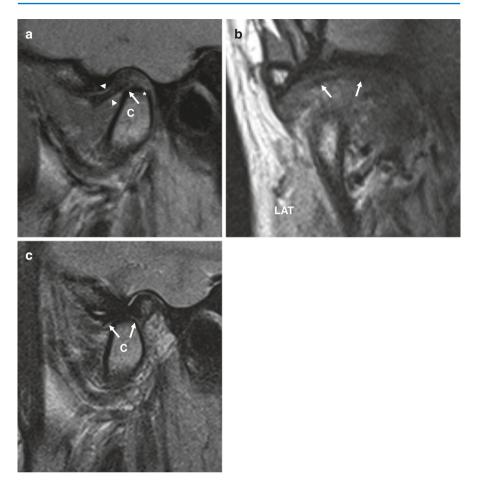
Disc displacement with reduction that is anterior without rotation. (a) Closed-mouth MR image showing anterior disc (arrow) displacement. The disc has a normal configuration, and the thin zone (arrowheads) is also anterior to the articulating surfaces of the condyle (C) and tubercle. Small erosion (asterisk) is noted on the posterior condylar surface secondary to abrasion of the condyle against the posterior band of the disc associated with reduction occurring with forward condylar rotation and translation. (b) Closed-mouth MR image. (b). Coronal image with the jaw closed confirming no rotational component of the disc (arrows). (c) On opening the disc (arrows) is now reduced (recaptured) with the thin zone of the disc articulating with the superior surface of the condyle (C) and tubercle. This is a T2-weighted image and shows synovial fluid in the upper joint space and the normal "bow tie" disc configuration. *LAT* lateral
